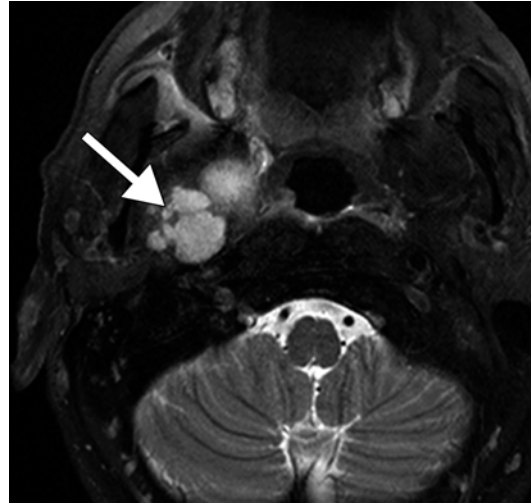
Parotid pleomorphic adenoma. Axial fat-suppressed T2-weighted MRI shows a bosselated T2 hyperintense mass arising from the deep lobe of the right parotid gland (*arrow*)
